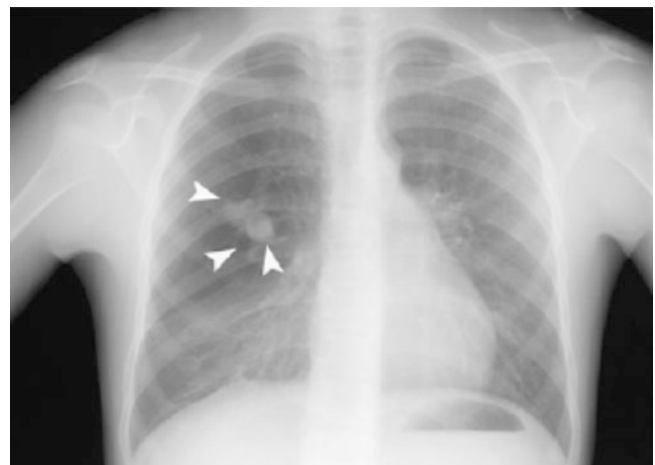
Fourteen-year-old boy with bronchial atresia found incidentally. Frontal chest radiograph shows a round opacity that appears to branch (arrowheads). Additionally, the surrounding lung is hyperlucent and exerts mild mass effect on adjacent lung
